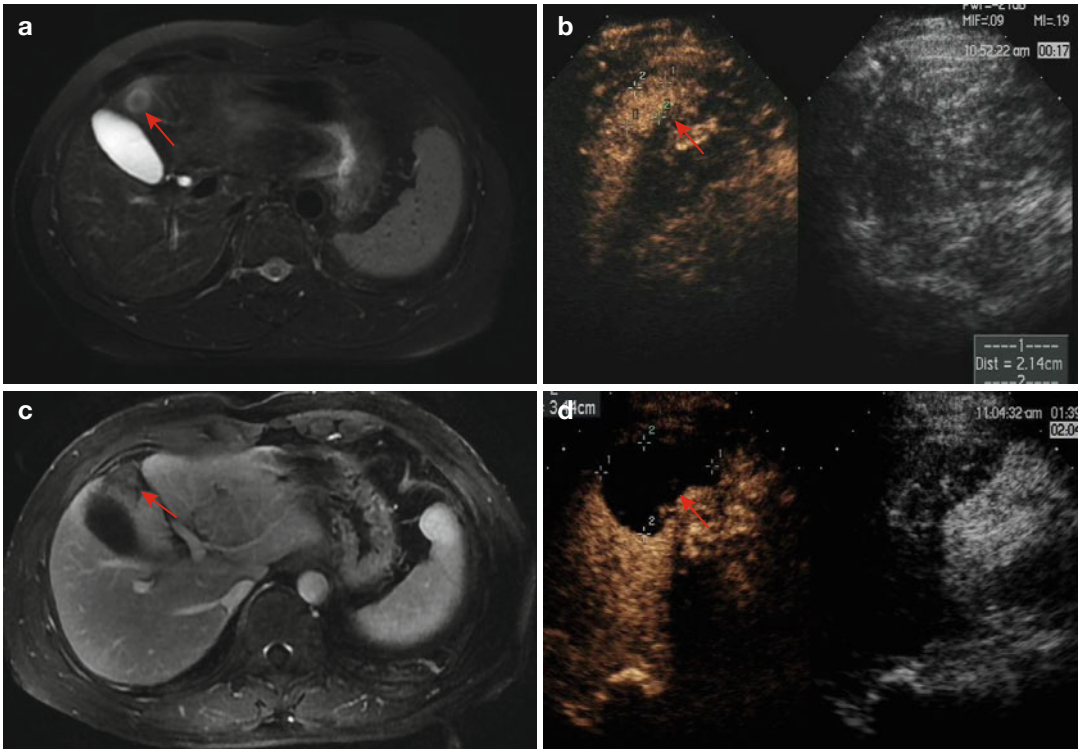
Images in a 50-year-old man who underwent CEUS guidance MWA of HCC. (a) Contrast-enhanced MRI shows a local nodule (*arrow*) in the left hepatic lobe. (b) Conventional ultrasound could not detect the tumor, but the CEUS arterial phase image shows a 2.1×1.4 cm
